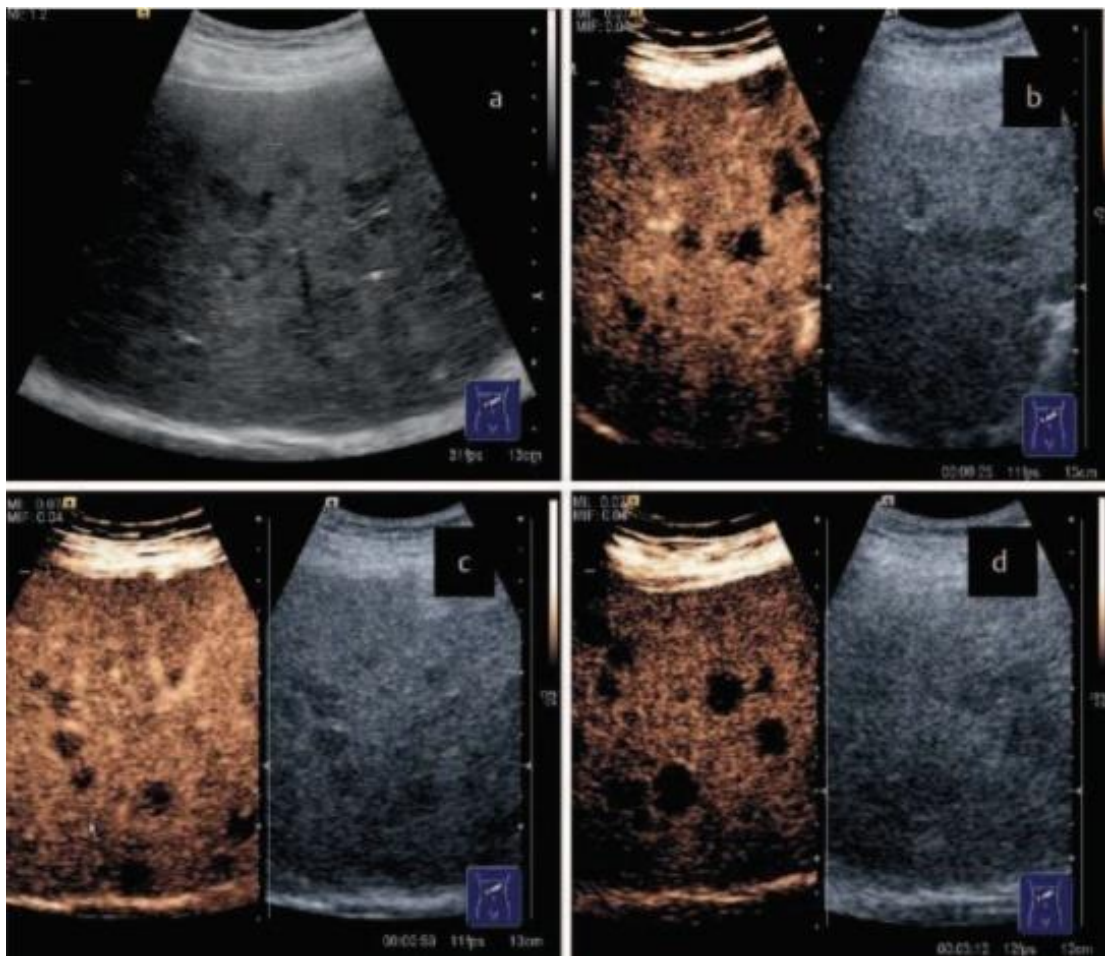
CEUS in malignant lesions (hypovascular metastases). a Conventional ultrasound: multiple hypoechoic liver masses; b Arterial phase: rim enhancement; c Portal phase: wash-out of the rim area; d Late phase: continued wash-out.
